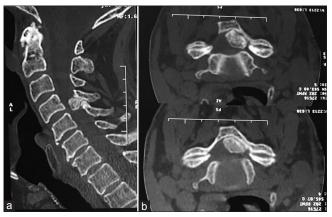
Cervical computed tomography (CT) scan. (a) Sagittal reconstructed CT showing a calcified mass between the spinal processes of C4 and C5 with canal compromise present at the site of the ligamentum flavum. (b) Axial CT demonstrated an oval-shaped calcified mass
